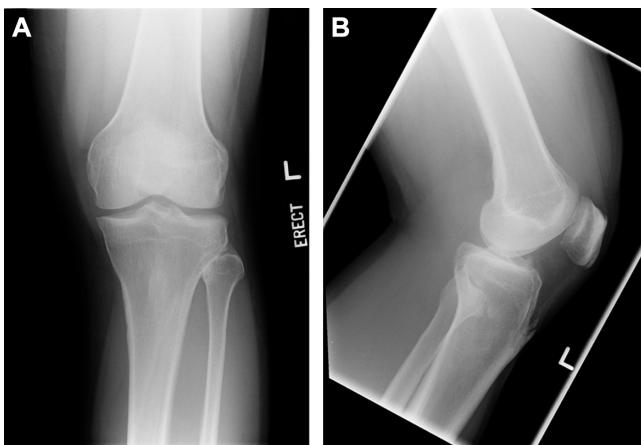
(A) Anteroposterior and (B) lateral radiographs of the left knee at the time of the anterior cruciate ligament injury.
